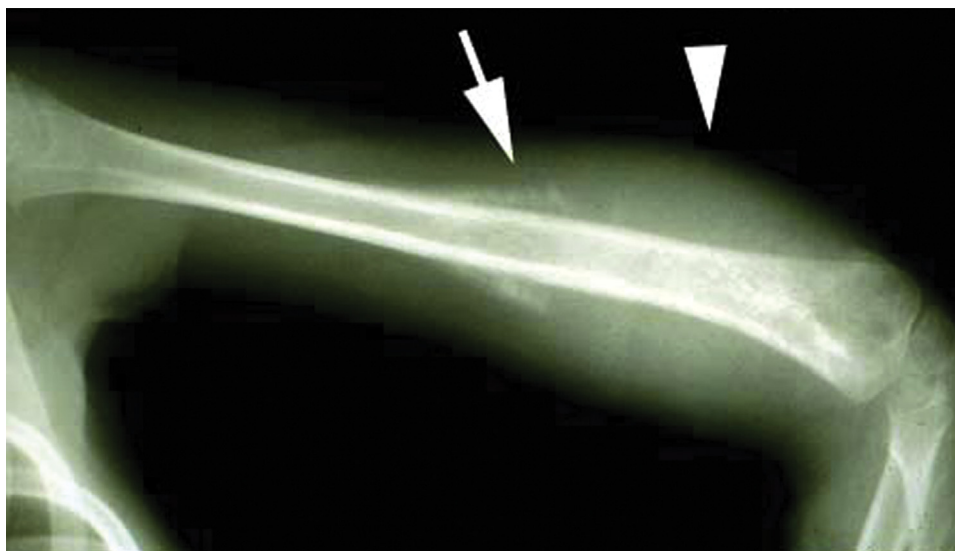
Ewing sarcoma of bone in a child. Plain radiograph shows a mass in the metadiaphyseal region of the distal humerus. Codman triangles (arrow) and extension of tumor into surrounding soft tissue (arrowhead) are seen.
